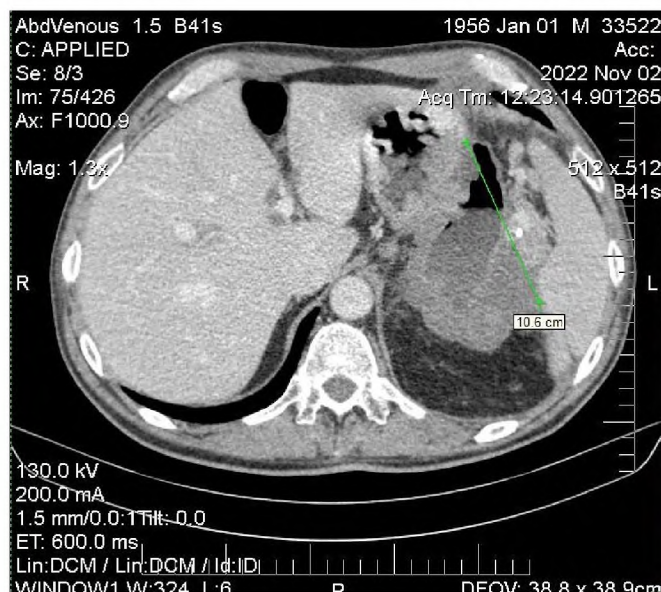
CT data 02.11.2022, tumor 106x95x86 mm
